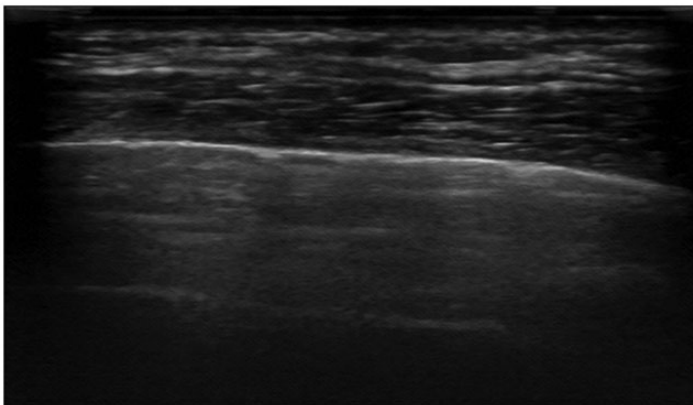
Doppler ultrasonography of the left breast showed glandular tissue hyperplasia. The mammary glands were arranged in a regular pattern with clear layers. The glands were an uneven thickness, presenting a smooth and intact boundary, with a thickened internal echo, disordered structure, and uneven distribution. No solid nodular or cystic formations were present.
